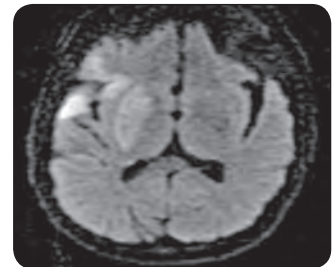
DWI of patient with right frontotemporal infarct
